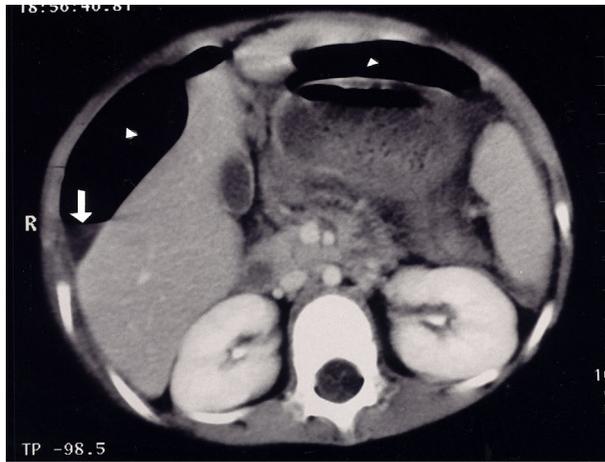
Abdominal CT shows extraluminal fluid (arrow) and free air (triangle).
